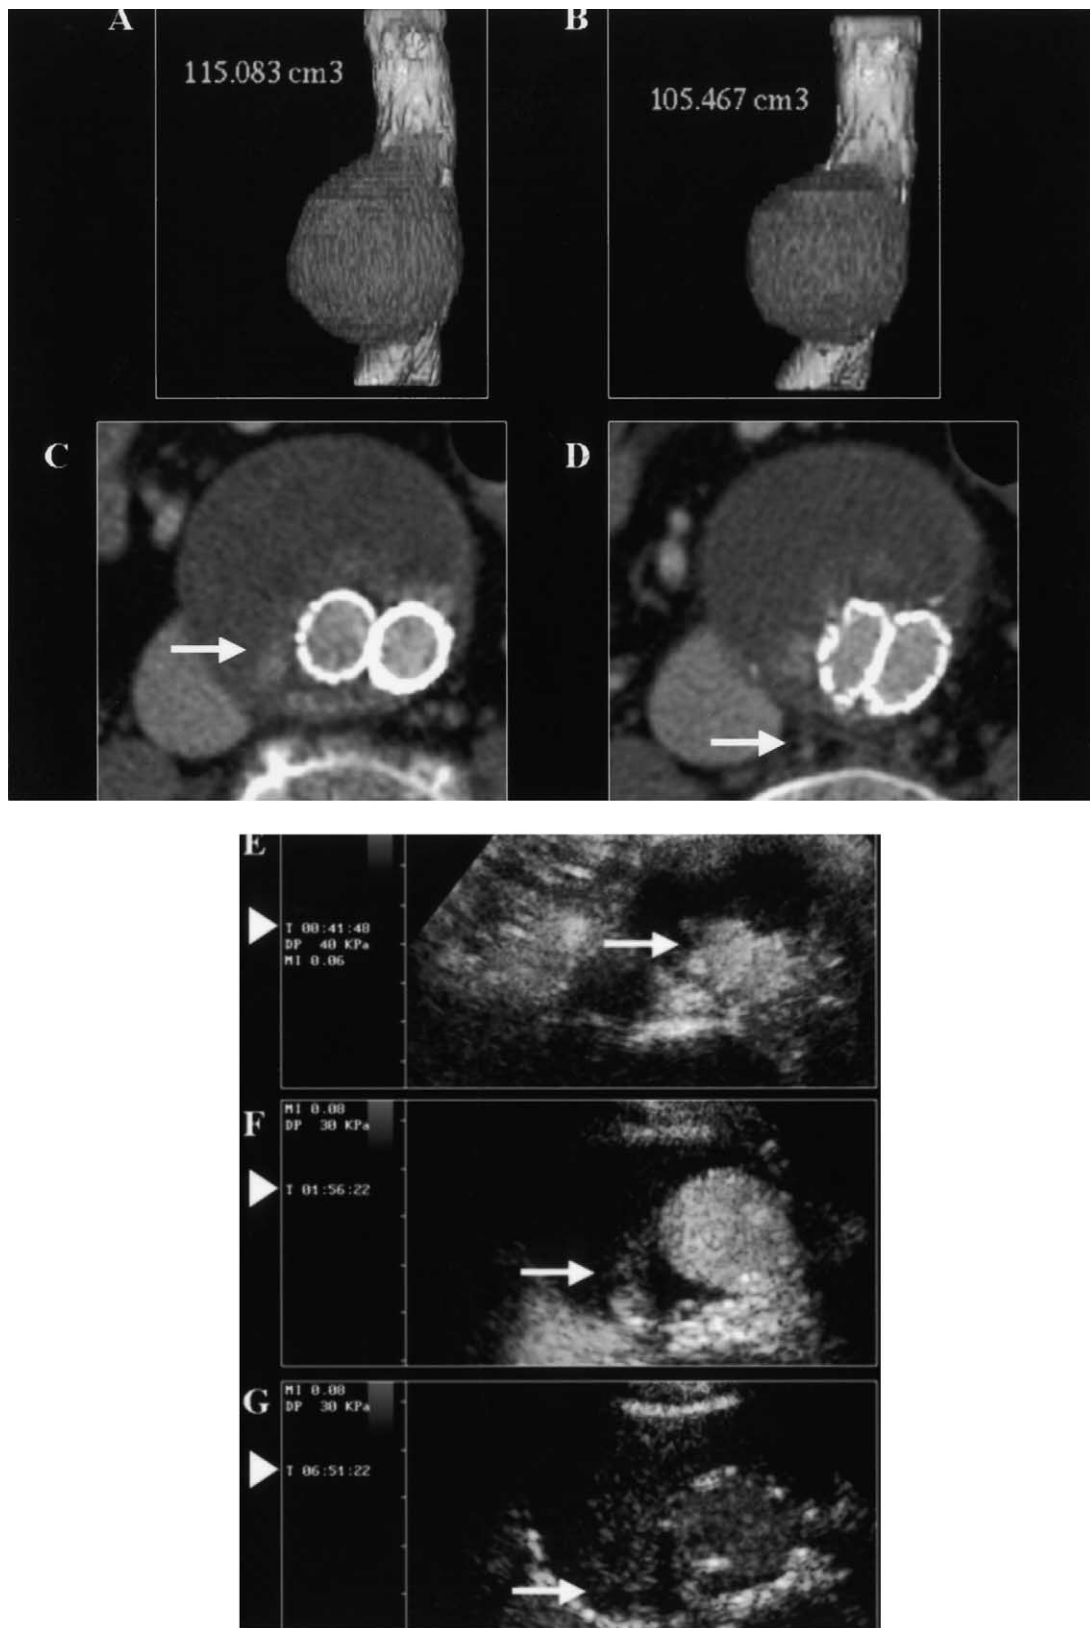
Patient 1, 78-year-old man with hyperdynamic endoleak. CTA shows a decrease in AAA volume at 20-month follow-up (B) compared to the 12-month follow-up control (A), despite the evidence of a type II endoleak visualized on the axial venous scans (C, *arrow*) fed by lumbar arteries (D, *arrow*). CUS shows the posterior endoleak (*arrows*) characterized by the wash-in at 40 seconds (E), progressive cavity filling (F), and washout at 360 seconds; the contrast material is no longer appreciated almost 10 minutes after contrast material administration. *Arrowheads* indicate the time (minutes and seconds) after injection of contrast material. At the *top left corner*, main parameters of CUS are indicated: mechanical index (*MI*) and derated pressure (*DP*).
